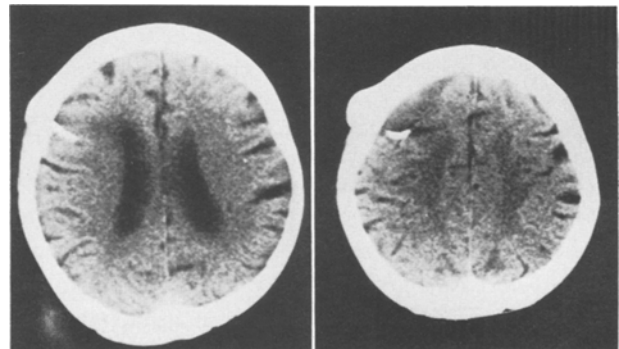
CT taken 9 months postoperatively shows the cyst has disappeared almost completely and the frontal lobe has been restored
